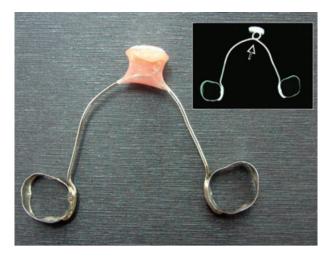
View of the appliance before cementation. Inner picture: radiograph of the appliance, revealing the position of the loop (arrow) within the acrylic resin.
